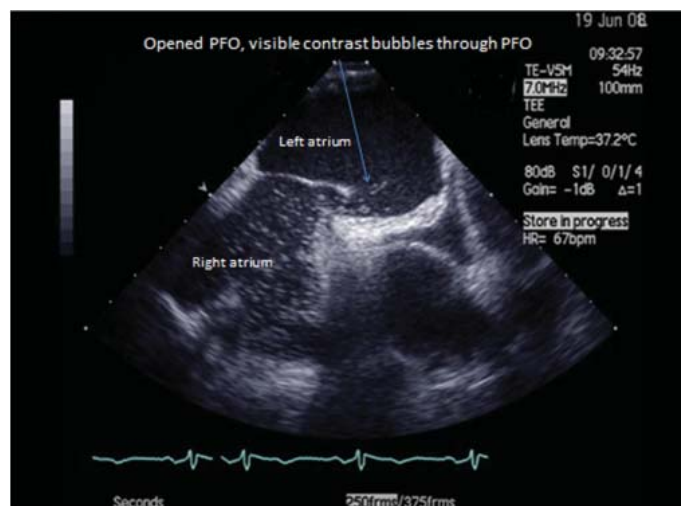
Transesophageal echocardiography picture of right-to-left passage of contrast bubbles through a PFO.
